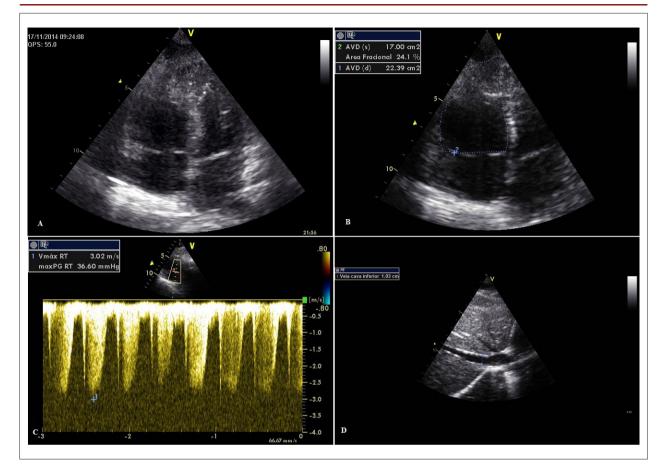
Transthoracic echocardiography: A) Increase of the right ventricle with normal left ventricle. B) Right ventricular systolic dysfunction with fractional area estimated at 24%. C) Tricuspid regurgitation to estimate the RV-RA gradient. D) Lower vena cava diameter to estimate right blood pressure.
